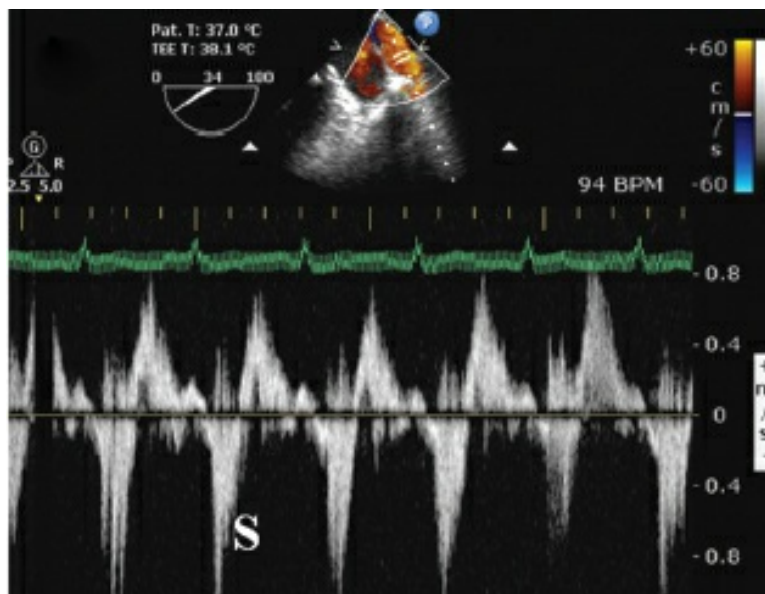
Pulsed wave Doppler from left pulmonary vein in a patient with severe mitral regurgitation. Note the systolic reversal (S).
